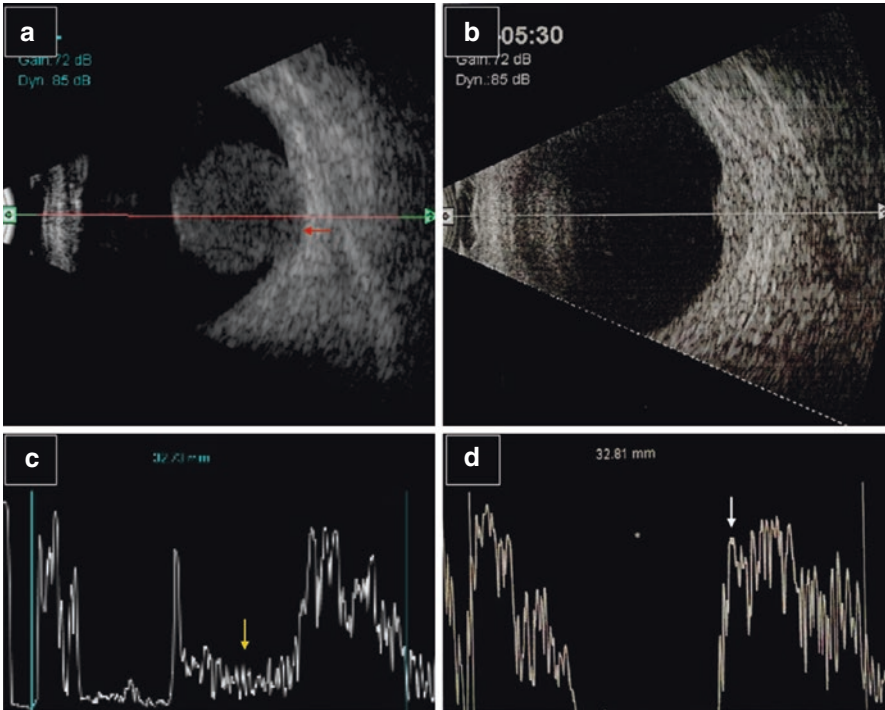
Ultrasonography of melanoma and hemangioma. (a) B scan of a case of choroidal melanoma. The tumor is mushroom-shaped. Choroidal excavation is evident as an area of loss of choroid at the base of tumor (red arrow). Height to base ratio is higher. (b) B scan of a case of choroidal hemangioma. The tumor is dome shaped. It is seen as an area of focal choroidal thickening in contrast to excavation in melanoma (c) A scan of choroidal melanoma showing high surface reflectivity and low internal reflectivity (yellow arrow). (d) A scan of choroidal hemangioma showing high internal reflectivity (white arrow)
